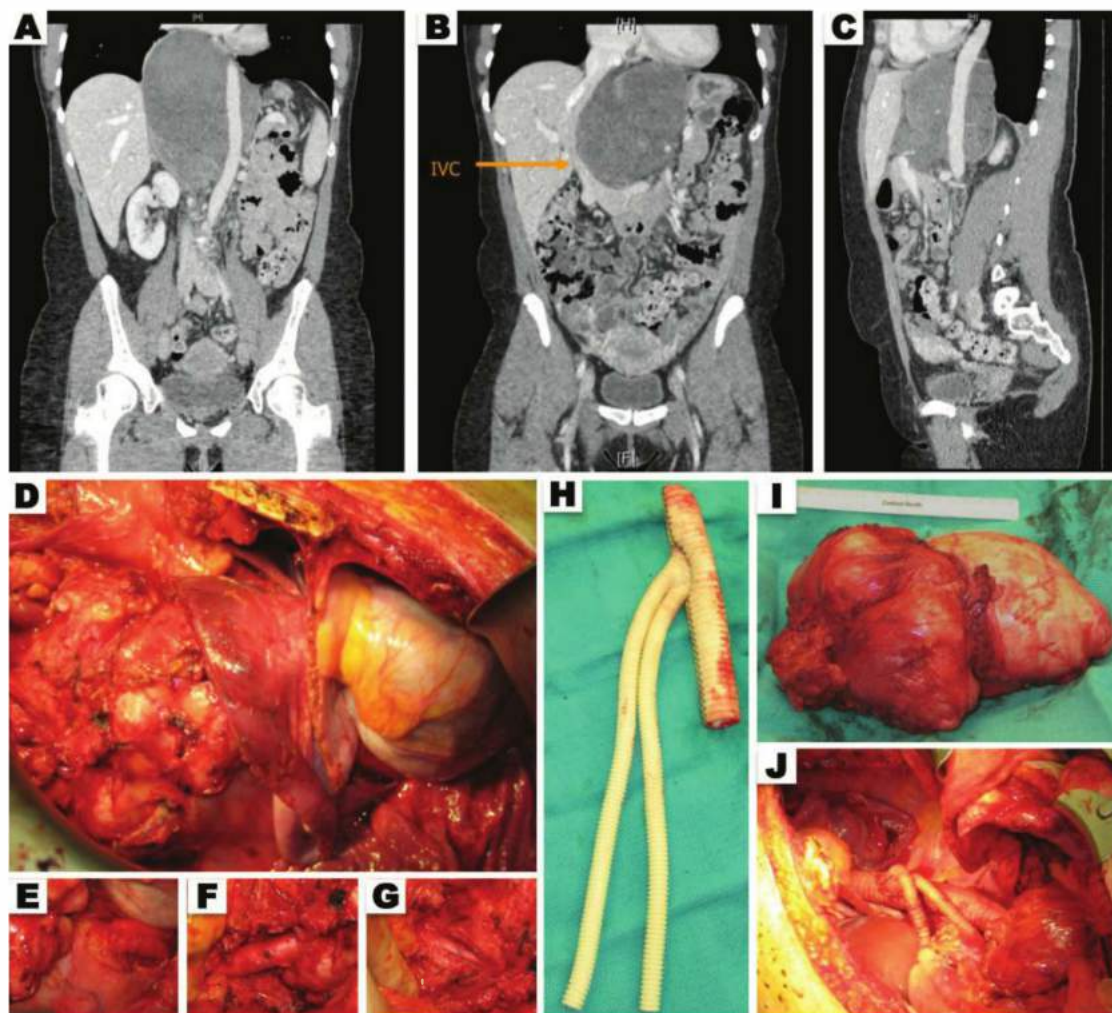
• Branched aortovisceral repair following resection of a large retroperitoneal thoracoabdominal myxoid sarcoma mass. A. Coronal abdominal computed tomography (CT) demonstrates large thoracoabdominal and mediastinal mass directly adjacent to major organ structures and the paravisceral aorta. B. CT demonstrates retroperitoneal portion of tumor mass displacing IVC toward the patient's right. C. Sagittal CT demonstrates circumferential involvement of the paravisceral aorta with the tumor mass. D. Left thoracoabdominal exposure reveals a large retroperitoneal mass extending proximally directly underneath the diaphragm. The supradiaphragmatic aorta (E), proximal left renal artery (F), and proximal SMA (G) were all exposed to facilitate tumor resection and aortic branched repair. H. Aortic branch graft was constructed on the operative back table by attaching a 14-mm bifurcated Dacron graft to the side of a 16-mm Dacron tube graft. Following en bloc resection of the mass along with associated aortic segment (I), the resected aortic segment was then repaired with the constructed graft. Branches were used for end-to-end anastomosis to the left renal artery and SMA.
